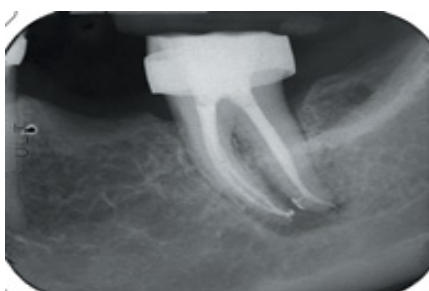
Radiograph after orthodontic band placed and endodontic therapy completed.
